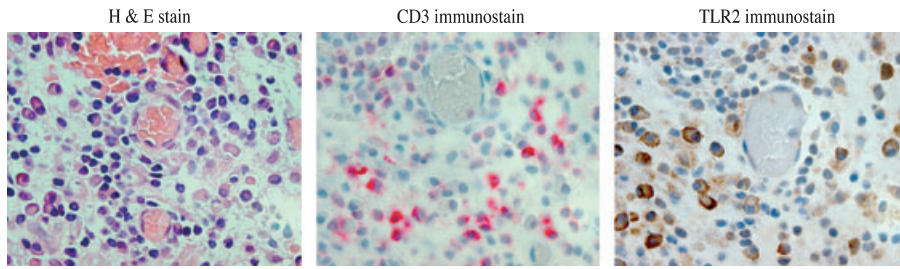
Representative adjacent sections of an asymptomatic periapical granuloma showing the association of CD3 T cells and TLR2⁺ mononuclear cells in the vicinity of a blood vessel (×1000).
